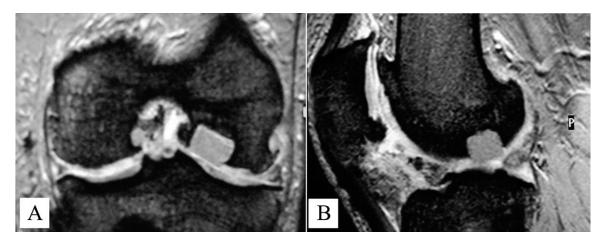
MRI of Cartiva® implants used in treating a focal defect in the femoral condyle. In a clinical evaluation of 65 patients, an average increase in IKDC knee score of 60% at mean follow-up of 30 months was seen (A: transverse section, B: sagittal section). (Figures courtesy of Carticept Medical)
